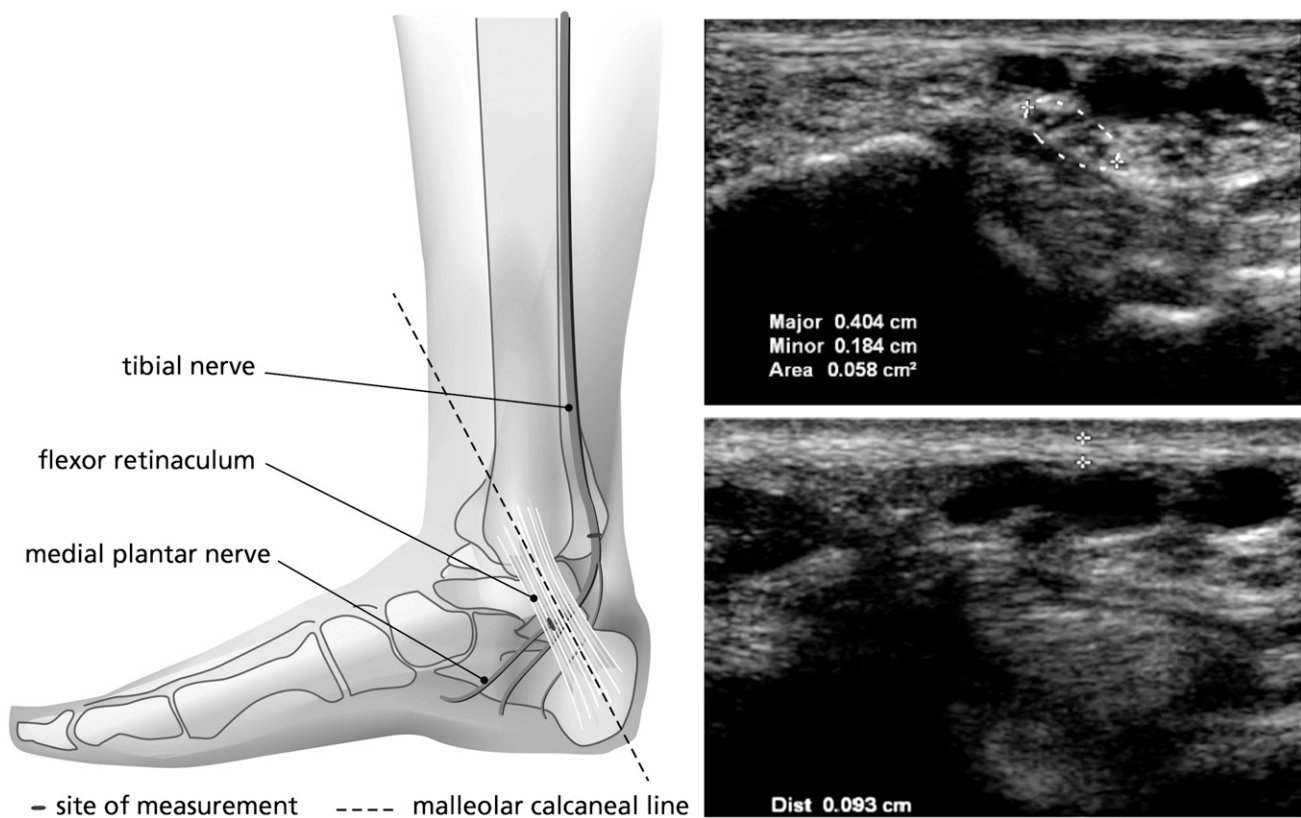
Left panel: Ultrasound probe placement. Upper right: in the ellipse, the tibial nerve is shown with corresponding measurements. Lower right: The thickness of the flexor retinaculum with corresponding measurement is shown between the marks.
